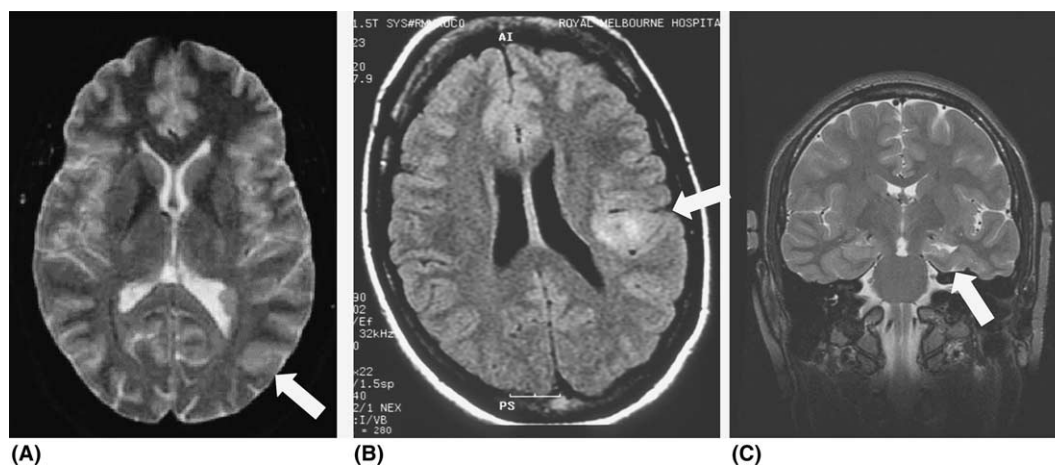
MRI images from the three cases: (A) demonstrated a region of focal malformation of cortical development in the left parietal and posterior temporal region (case 1); (B) demonstrated a focal malformation of cortical development in the left frontal operculum (case 2); (C) demonstrated changes consistent with left mesial temporal sclerosis (case 3).
